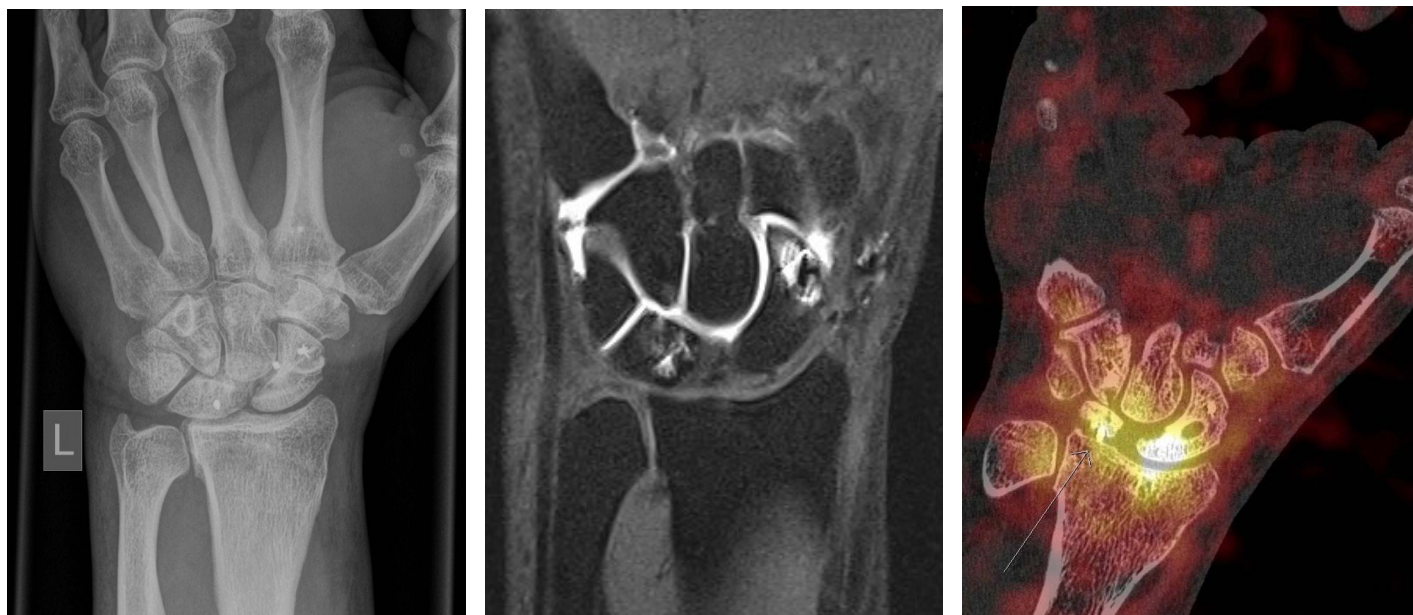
Images of a 45 year old man who complained about persisting pain after having undergone two surgeries to repair a traumatic scapholunar (SL) rupture. The patient presented to our clinic one month after the initial trauma. He received a delayed blatt capsulodesis repair with temporary K-wire fixation. A. Postoperative radiographs after K-wire removal showed a persisting SL insufficiency. Thus, a brunelli procedure was performed. Postoperatively, the patient was still complaining about pain over the dorsal aspect of the wrist. B. The patient then received an arthro MRI, which showed no pathologies and an intact osseous anatomy. There was no evidence of a persisting SL insufficiency. However, the imaging quality for this imaging technique was impaired in some regions due to the artifacts caused by the implanted metal materials. C. SPECT-CT then showed the dislocation of one of the originally implanted mini suture anchors.
